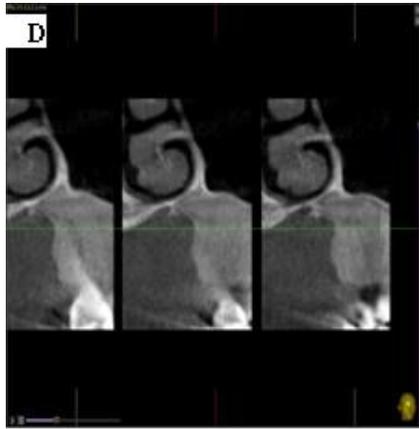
CBCT Images. Axial view showing the lack of trabeculae bone (A). Panoramic view (B). Sections corresponding to zones 2.5 and 2.6 (C and D).
